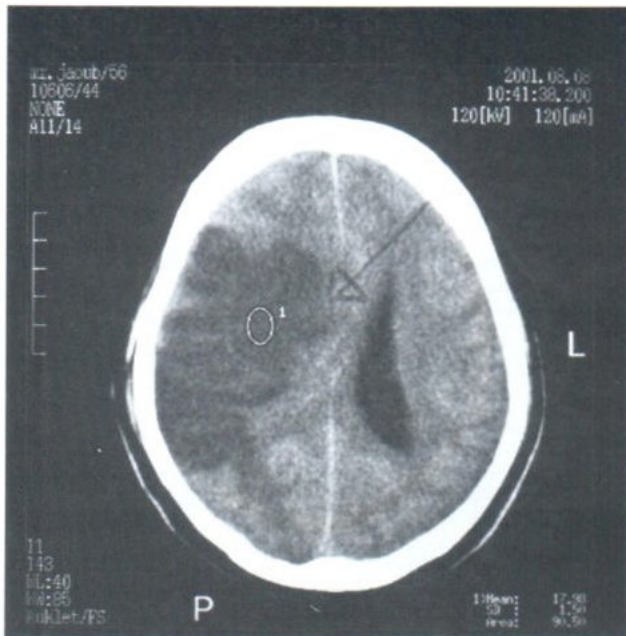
The same patient followed up CT at 48 hours developed subsequent large infarction
